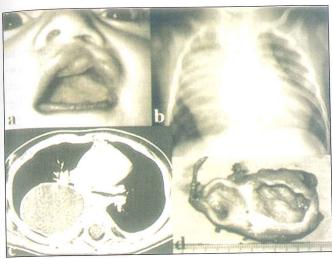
Chest X-ray and tomography showing a posterior mediastinal cystic mass and hemivertebra, vertebral cleft and scoliosis (b-c) of case 1 with congenital lip and palate cleft (a) and the excised mass (d).
